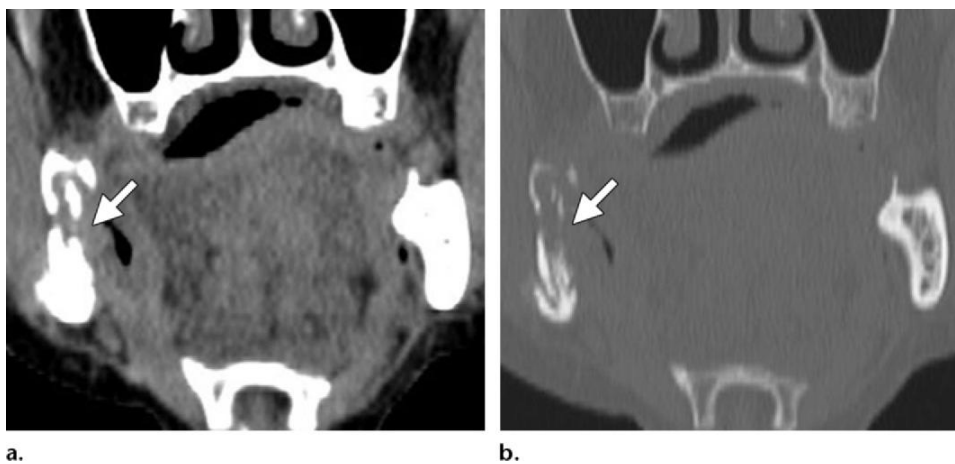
Osteoradionecrosis of the mandible after chemoradiation therapy in a 64-year-old man with squamous cell carcinoma of the right tonsil. Coronal CT images obtained with soft- tissue (a) and bone (b) windows show a focal lytic area with cortical destruction and a pathologic fracture in the right mandibular ramus (arrow).
